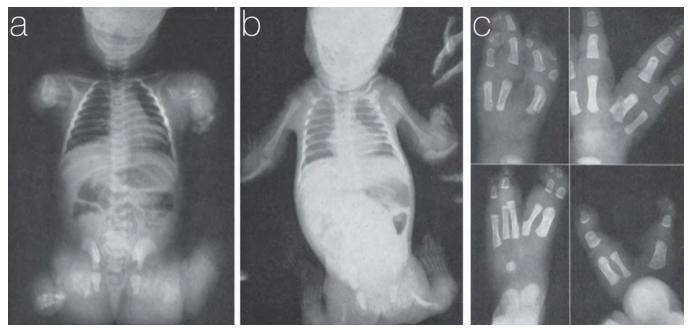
Radiographs of thalidomide-induced birth defects: (a) Phocomelia of all limbs (b) Bowing and angulation of long bones (c) Cleft hands and feet with fusion of some digits.¹¹
